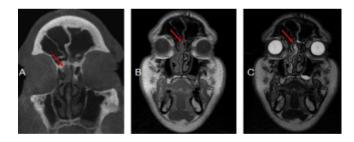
CT-scan showed a low-density lesion on the right side of the ethmoidal plate next to the olfactory cleft without evidence of bone erosion (Figure 2A). MRI provided clear structural details showing inhomogeneous intensity for the presence of low-density areolas in T1, and high-density areolas in T2
